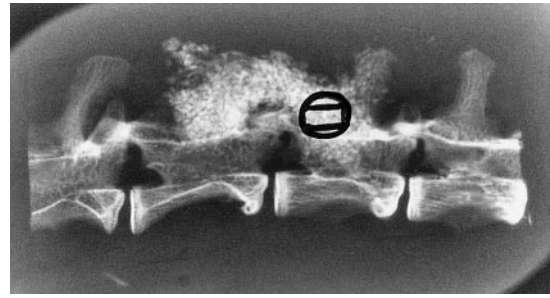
Radiograph of sample embedded in methylmethacrylate. The area for histomorphometric measurements is visualized
